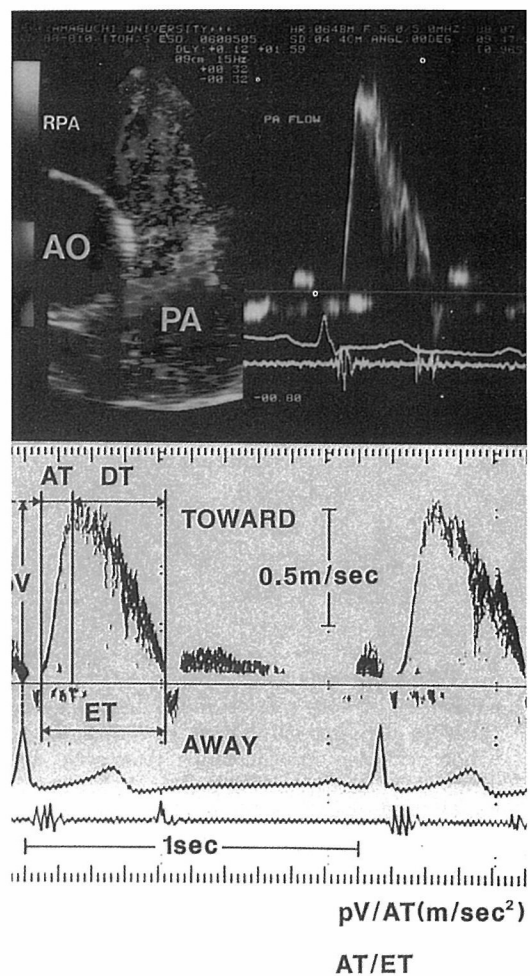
Transesophageal Doppler color flow image and pulsed Doppler echocardiogram in the main pulmonary artery (upper panel), and measurements of flow signal (lower panel). PA: main pulmonary artery, RPA: right pulmonary artery, AO: aorta, pV(m/sec): systolic peak flow velocity, ET(sec): ejection time, AT(sec): acceleration time, DT(sec): deceleration time, pV/AT(m/sec<sup>2</sup>): mean acceleration time, AT/ET: the ratio of acceleration time to ejection time.
